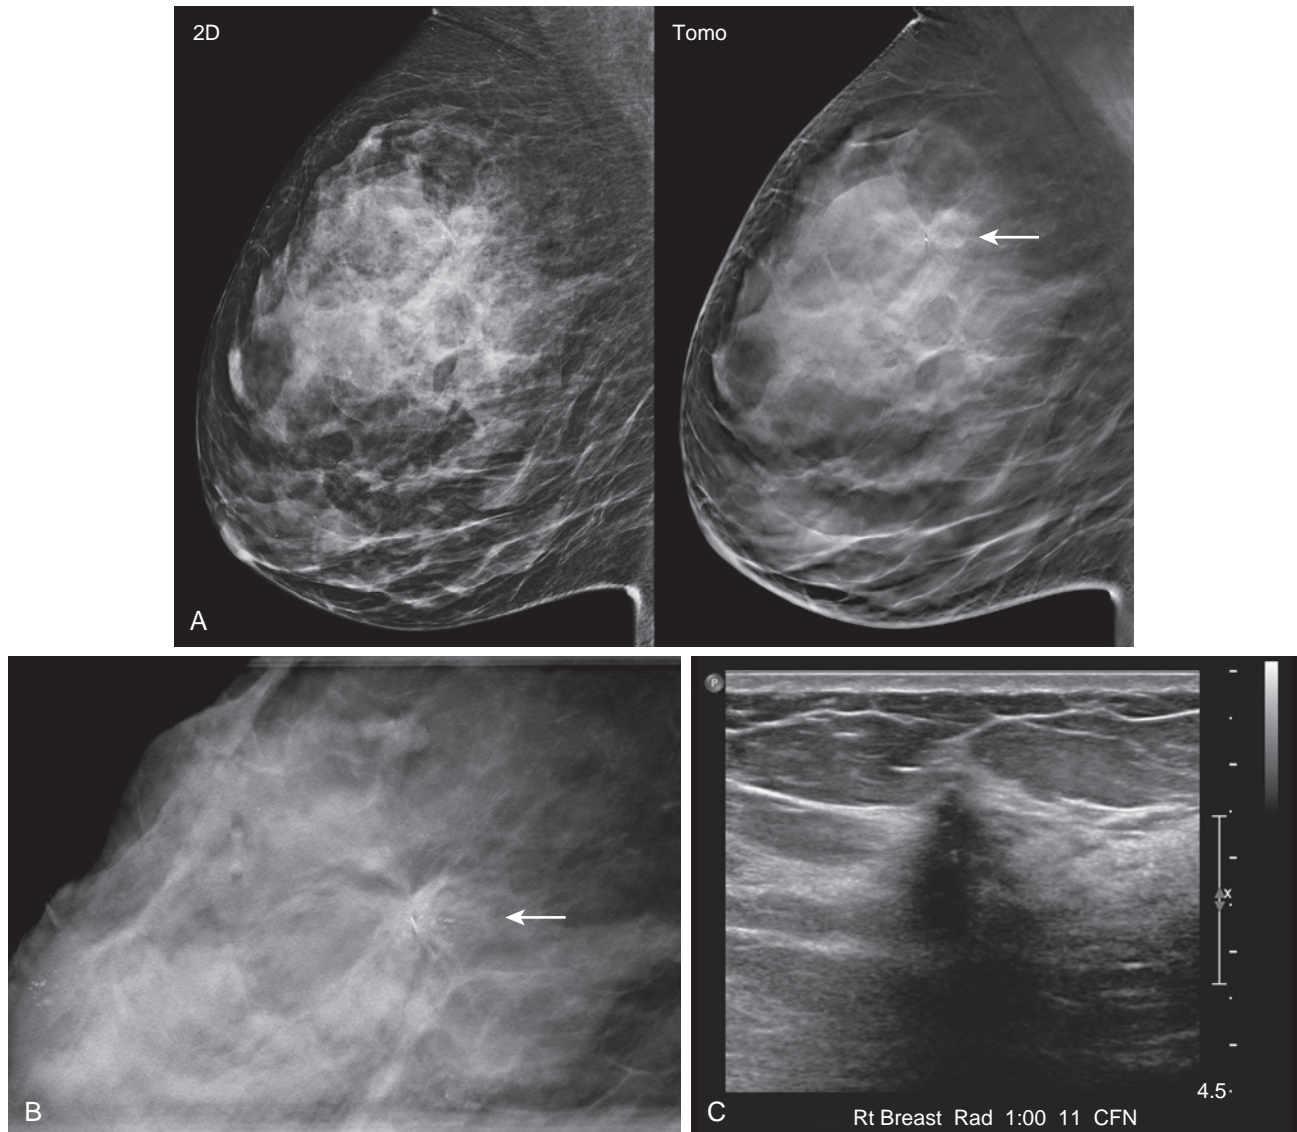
Changing scar following benign biopsies: invasive ductal carcinoma. A 54-year-old woman with history of benign excisional and subsequent stereotactic biopsy for calcifications. (A) Two-dimensional and tomosynthesis images show a biopsy site clip, nearby amorphous calcifications, and minimal presumed postbiopsy distortion (*arrow*). (B) One year later spot compression tomosynthesis demonstrates increasing architectural distortion (*arrow*). (C) Ultrasound confirms a suspicious hypoechoic mass with posterior shadowing. Final diagnosis is invasive ductal carcinoma with calcifications, 1.3 cm, ER/PR+, Her2–, and sentinel lymph node micrometastases.
